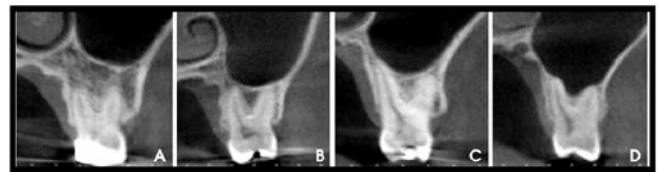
CBCT images show 4 types of vertical relationships between the root of the maxillary molars and the sinus floor. A. Type 0, the root is separate from the sinus floor. B. Type 1, the root is in contact with the sinus floor. C. Type 2, the root is projecting laterally along the sinus cavity, but is outside the sinus borders. D. Type 3, the root is projecting into the sinus cavity.
